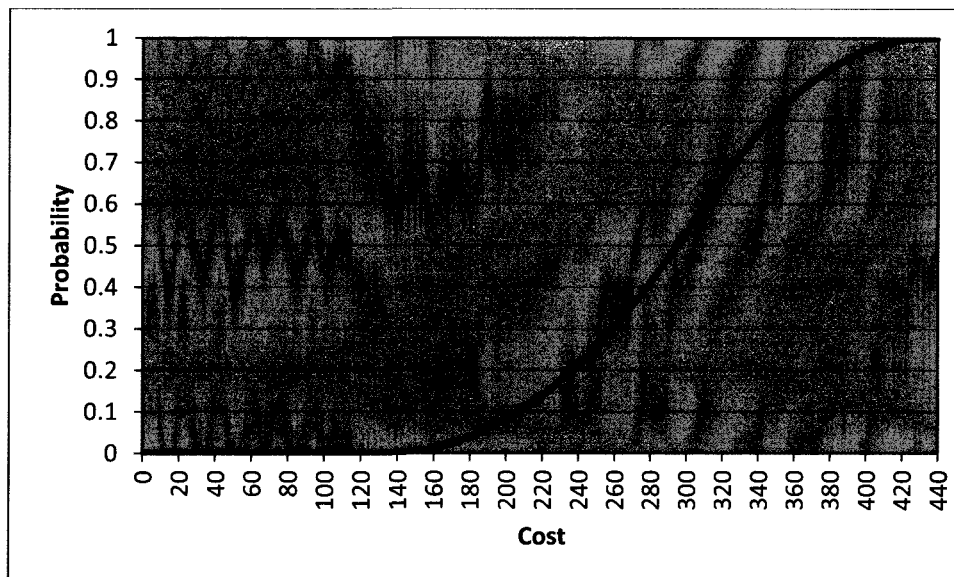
Compression ultrasonography (CUS) direct cost cumulative probability.
